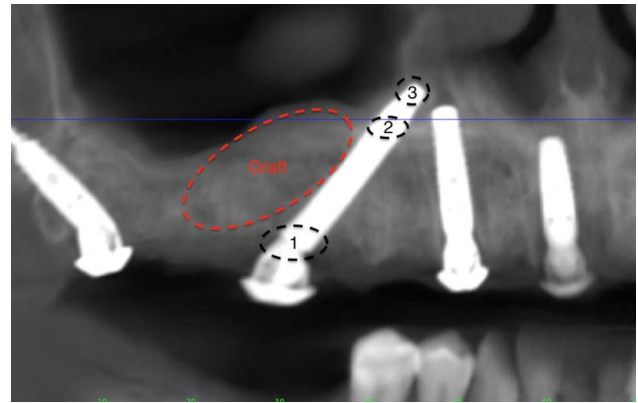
Radiograph of the trans-sinus implant and the associated graft placed within the maxillary sinus with points of engagement with the three cortices.
